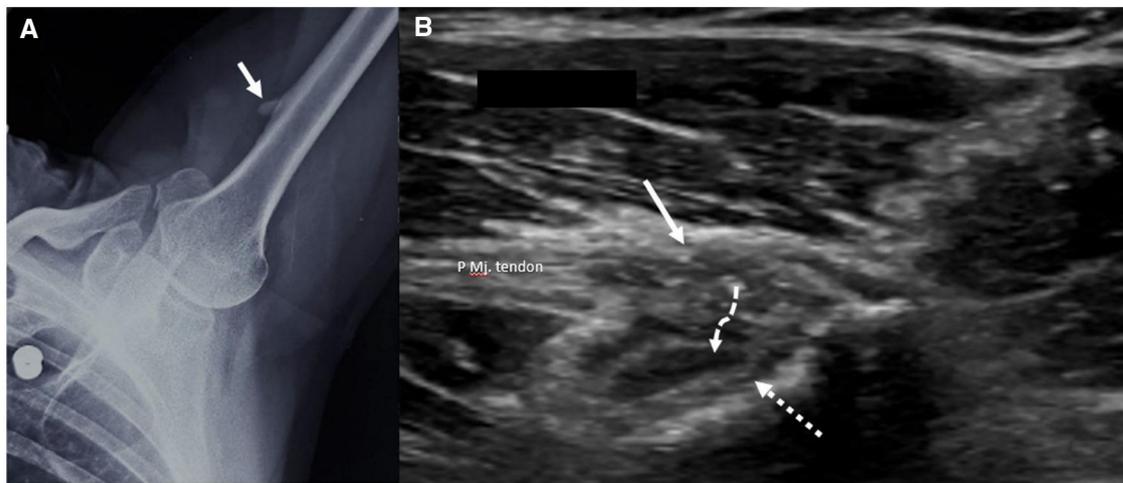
Conventional axial view radiograph of the shoulder (A) showing a small, well-defined focus of calcification at the insertion site of the pectoralis major tendon (white arrow). The ultrasound images of the proximal arm in longitudinal plane (B) show calcific foci at pectoralis major insertion site (white arrow) with potential migration (curved dashed arrow) into floor of the bicipital groove (dashed arrow).
